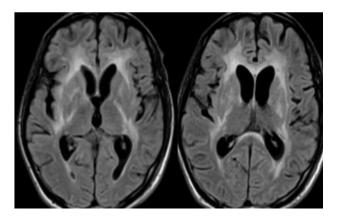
HIV encephalopathy; axial FLAIR (fluidattenuated inversion recovery) image demonstrating diffuse parenchymal atrophy with periventricular white matter hyperintensity (plaques of white matter demyelination).⁵
